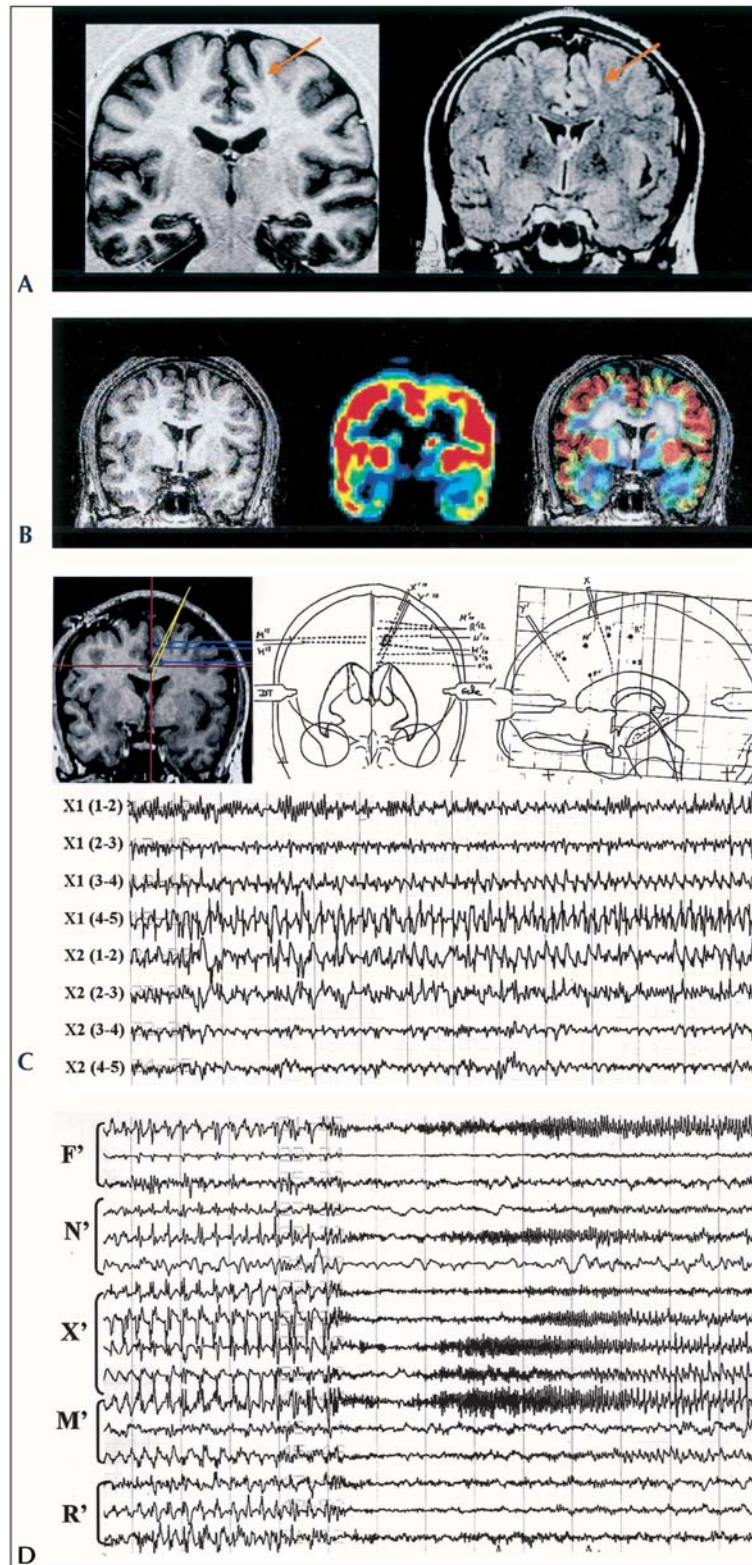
Case n°2; A. MRI, coronal slices, T1 and FLAIR sequences: mild gyral abnormality on the left mesial pre-motor area (arrow). B. FDG-PET, axial slices: mild hypometabolism concordant with the gyral abnormality (SHFJ, CEA, Orsay). C. SEEG: interictal continuous rhythmic activity located in the abnormal gyrus: electrode X, contacts X1(4-5) and X2(1-2). D. Spontaneous seizure: ictal discharge onset in the same area after a brief spreading of RSDs, early propagation to the adjacent areas (M'1).
